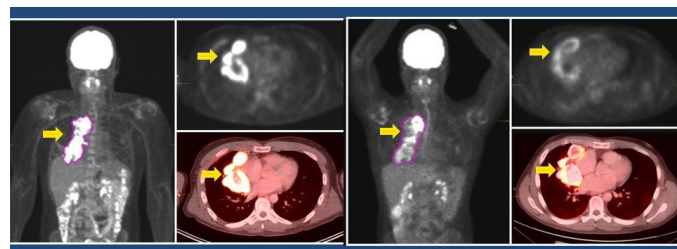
Sodium Fluoride PET/CT scan pre and post Radium 223 alpha particle therapy in a patient with osteosarcoma.
